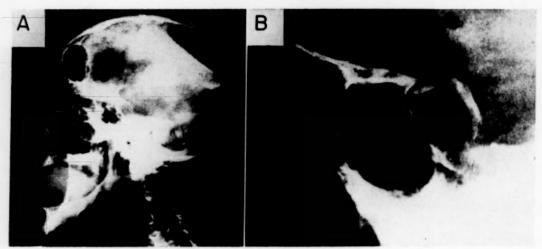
Case i. A, lateral roentgenogram of skull. B, enlarged view of sella turcica.
